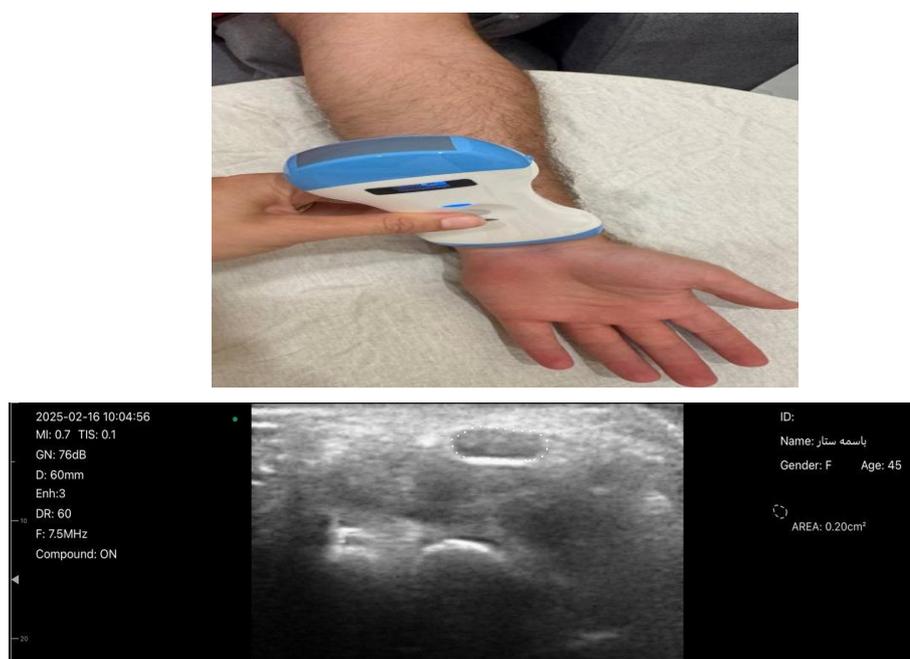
Assessment of the median nerve and characterizing its visualization through ultrasound scans.
